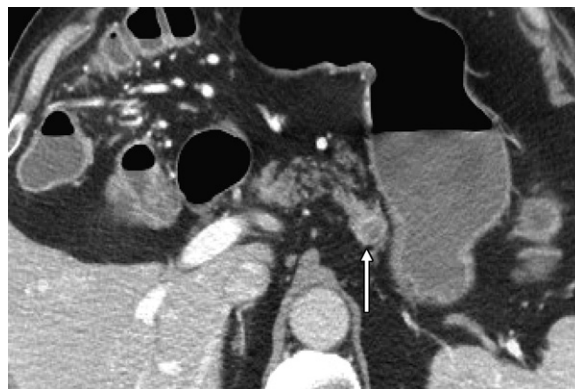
Axial CT image shows an incidental enhancing pancreatic neoplasm (arrow), which was missed during initial interpretation and identified at follow-up by a different radiologist. The lesion represents a neuroendocrine tumor.
